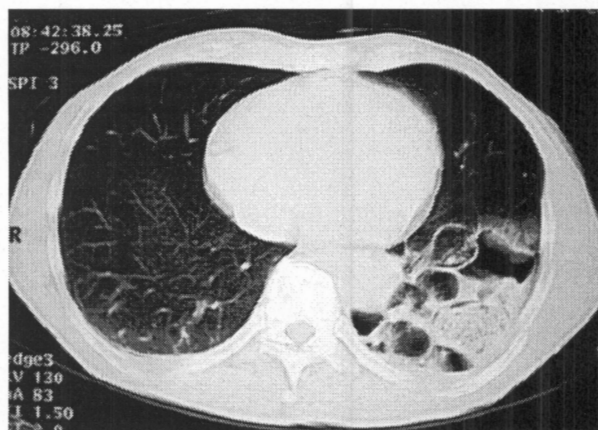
Computed tomography showed the gas image that allows suspicion of an existing bowel in the thoracic space.
